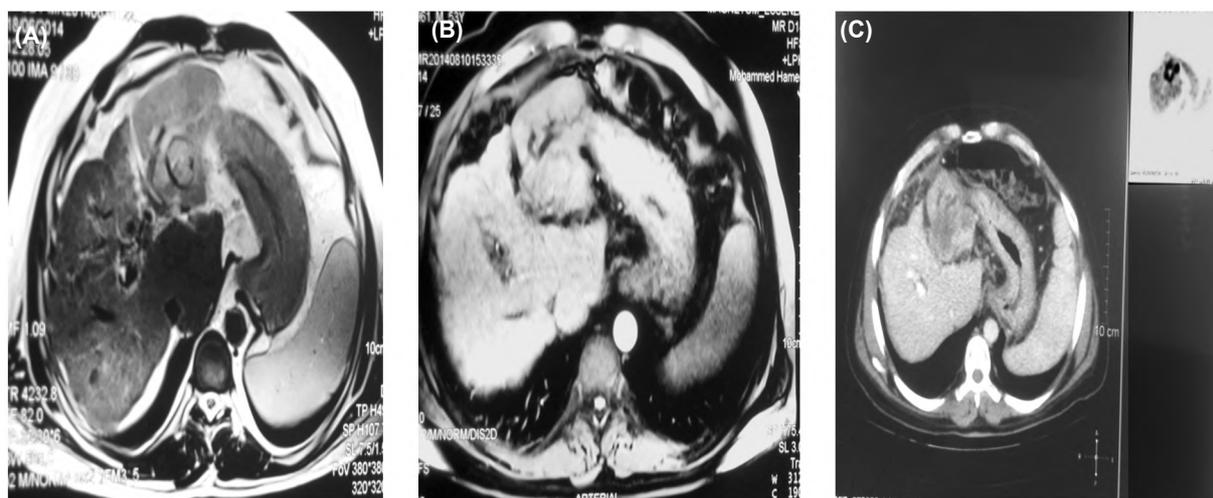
(A): MRI scan showing left lobe lesion with segmental left portal vein thrombosis and cholestasis. (B): MRI scan 3 months post radioembolization showing stable lesion size yet with differential tumoral enhancement. (C): PET/CT scan 6 month post radioembolization showing partial response, with tumor size reduction and residual peripheral activity.
